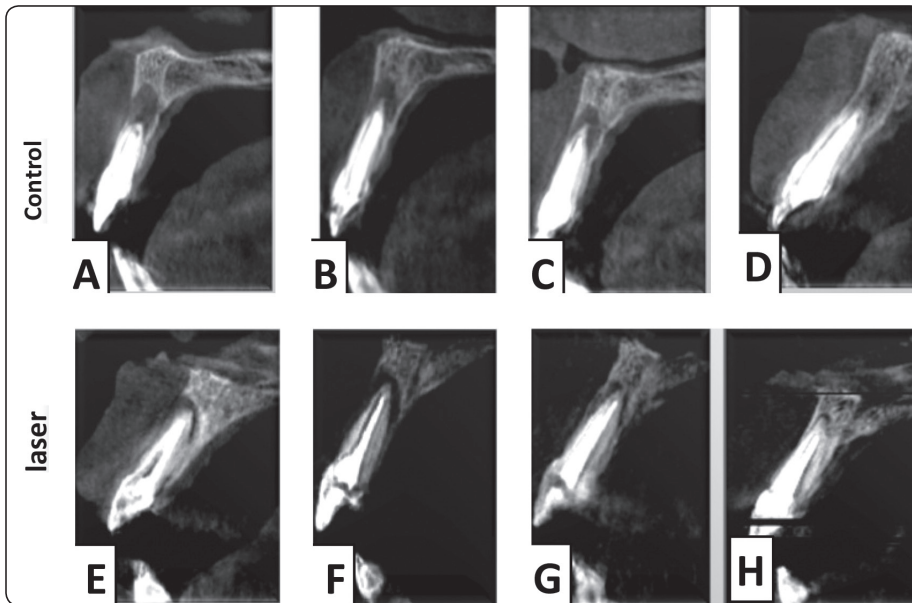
Cone beam follow up sagittal image for control case and laser case over 12 month period. (A,E) just after obturation, (B,F) one month after obturation (C,G) three month after obturation, (D,H) twelve month after obturation
